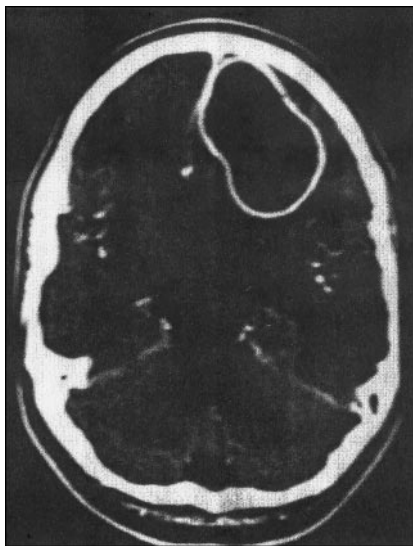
Computed tomography with contrast enhancement of a frontal lobe abscess that developed as a complication of sinusitis in a 12-year-old girl.
